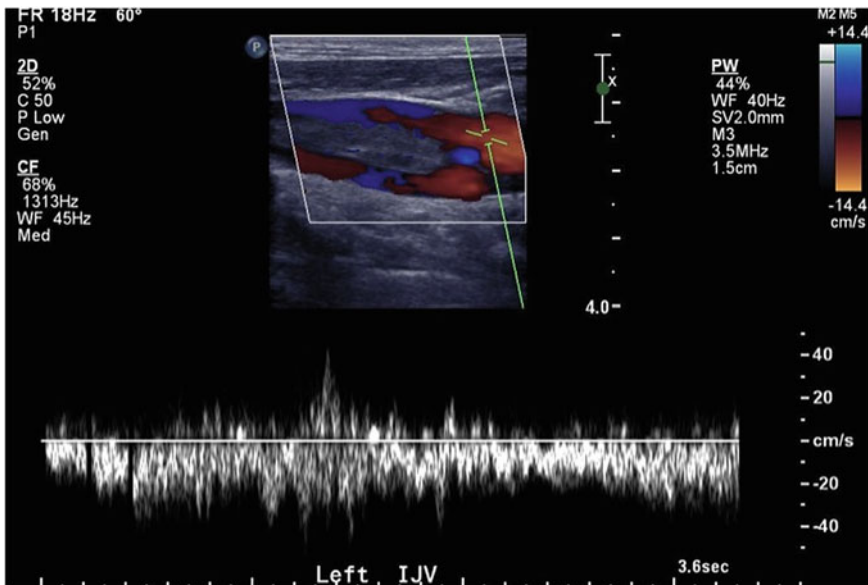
Color Doppler shows partially occlusive thrombus in the internal jugular vein
